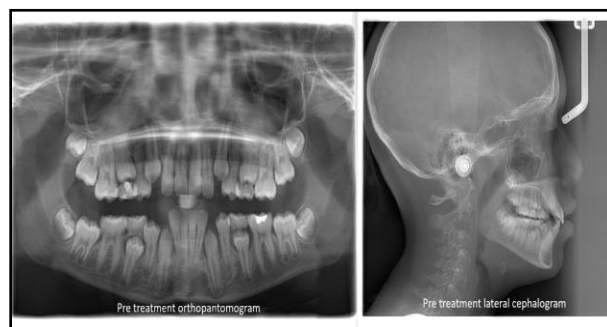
Pre-treatment Orthopantomogram & Lateral cephalogram
